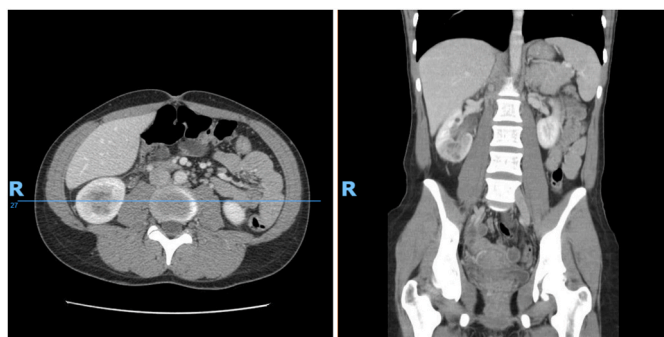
CT abdomen and pelvis with contrast showing a 2.4 cm lower pole lesion in the right kidney.
